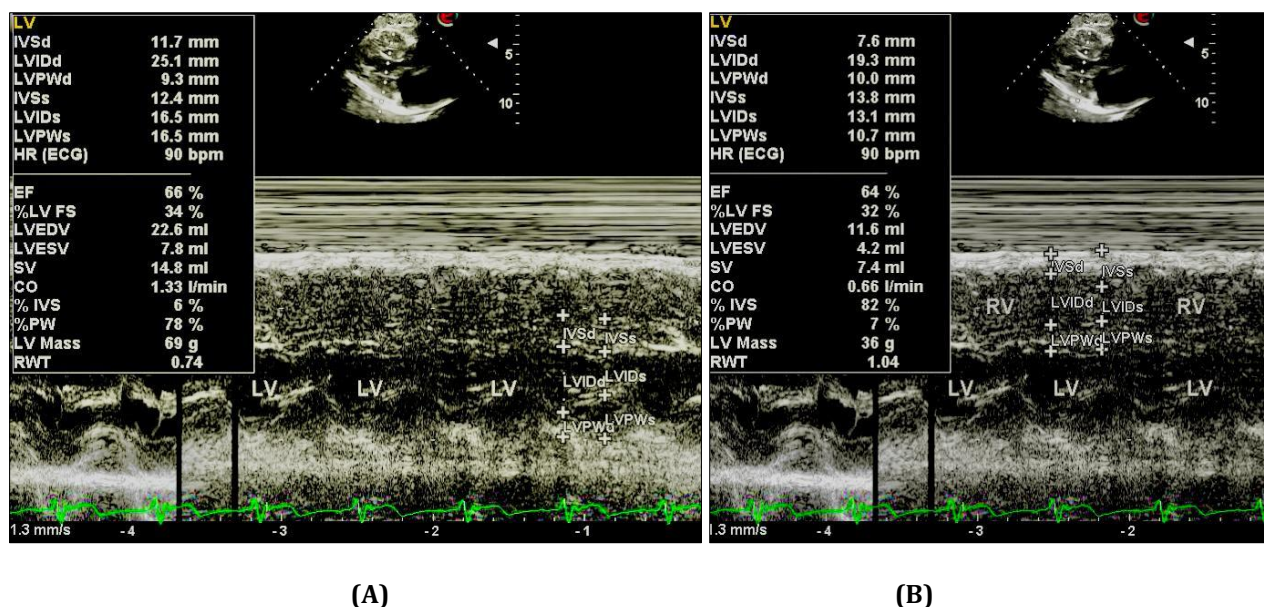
M-mode echocardiography (A) Small LV cavity size with normal LVEF = 66 %; (B) Small RV cavity dimension with normal RVEF = 64 %
